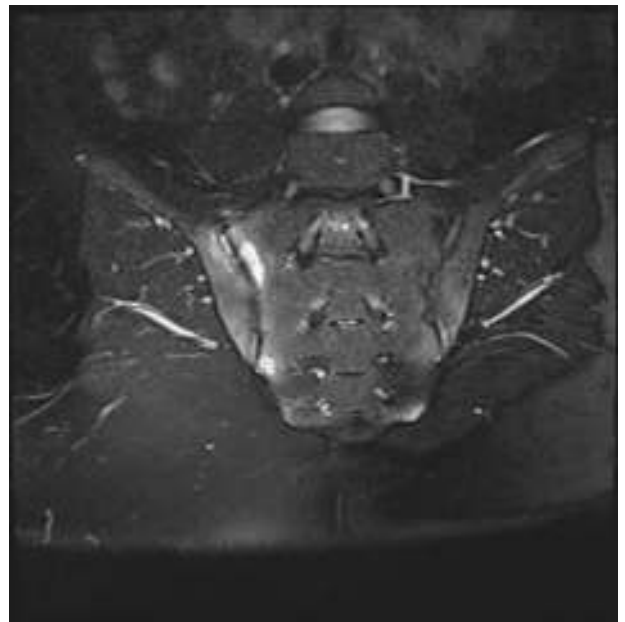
Sacroiliac joints MRI showed bilateral sacroiliitis.
